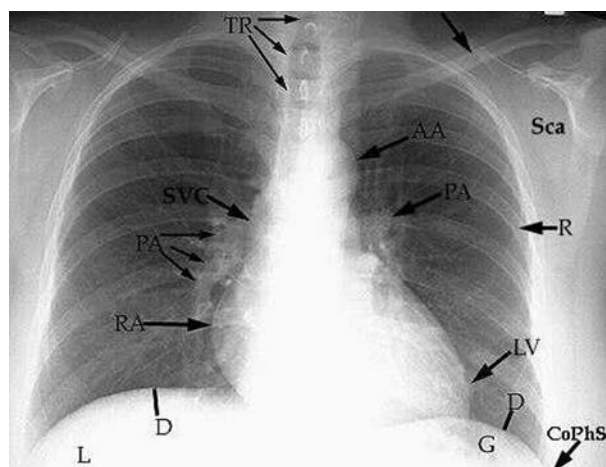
The normal X-ray of the chest (PA — pulmonary artery; TR — trachea; CL — clavicle; AA — aortic arch; SVC — superior vena cava; RA — right atrium; CoPhS — costophrenic sulcus; LV — left ventricle; D — diaphragm; G — gastric air bubble; L — liver; Sca — scapula; R — rib).
